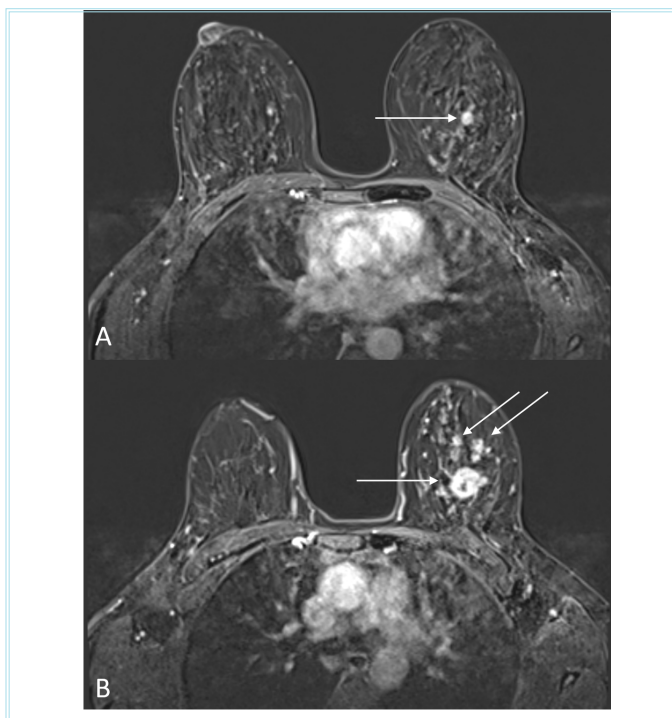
Contrast-enhanced breast magnetic resonance imaging images of a 63-year-old female patient diagnosed with ductal carcinoma *in situ* (DCIS). A) A subcentimetric enhancing solid lesion in the central area of the left breast is observed (arrow). B) In more superior sections, larger and multifocal enhancing lesions are observed in the same patient (arrows). The pathological results of these lesions were consistent with DCIS.
